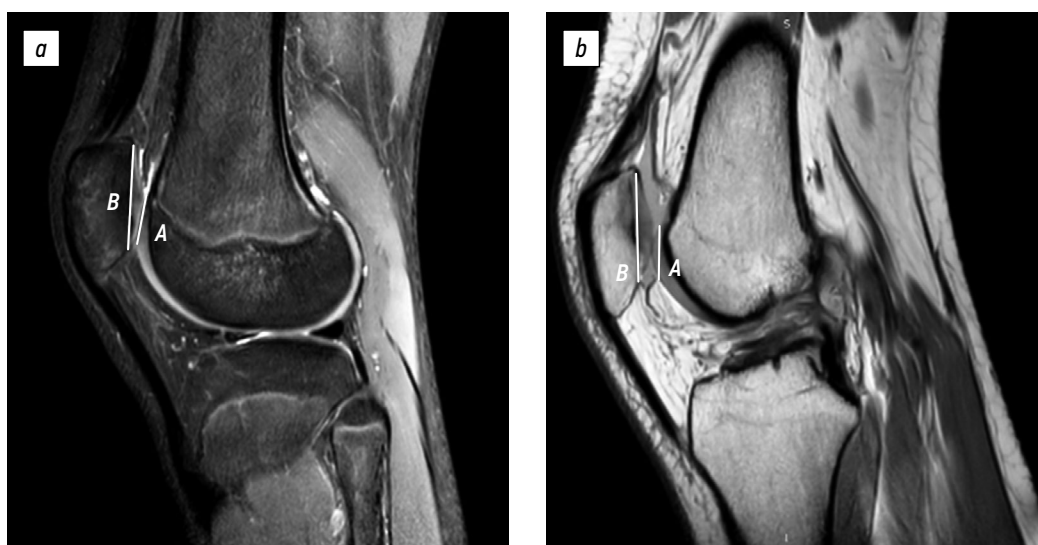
Patellotrochlear index on magnetic resonance imaging: a , 16-year-old female with patellar instability. Patellotrochlear index value: 11.4%; b , 15-year-old male with anterior cruciate ligament injury. Patellotrochlear index value: 39.1%. A , length of the trochlear articular surface in contact with the patellar articular surface; B , length of the patellar articular surface (patellar height).
